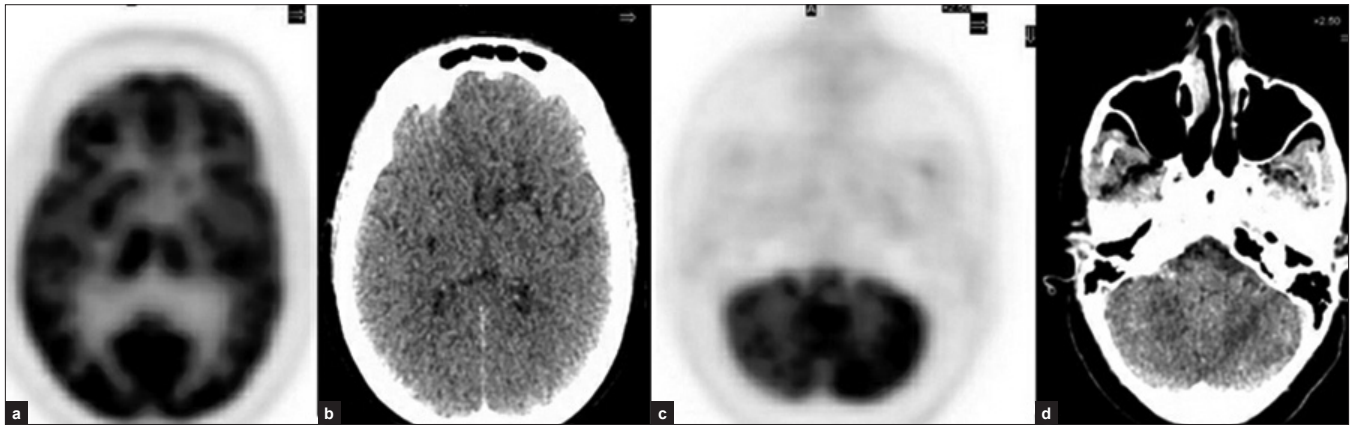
55-year female Ca right ovary post-op, post-chemo; (a, b) Axial plain PET and CT images showing hypometabolism in the left basal ganglia region corresponding to mild hypo-density on CT in the left MCA territory (infarct); (c, d) Axial plain PET and CT images showing hypometabolism in the entire right cerebellar hemisphere which appears normal on CT consistent with CCD
